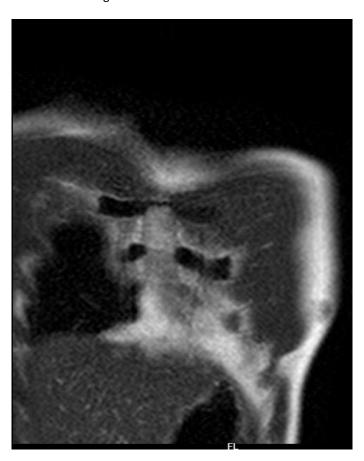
MRI Coronal view- Bulky inferior fibres of left serratus anterior muscle with ill defined hyper intensities
